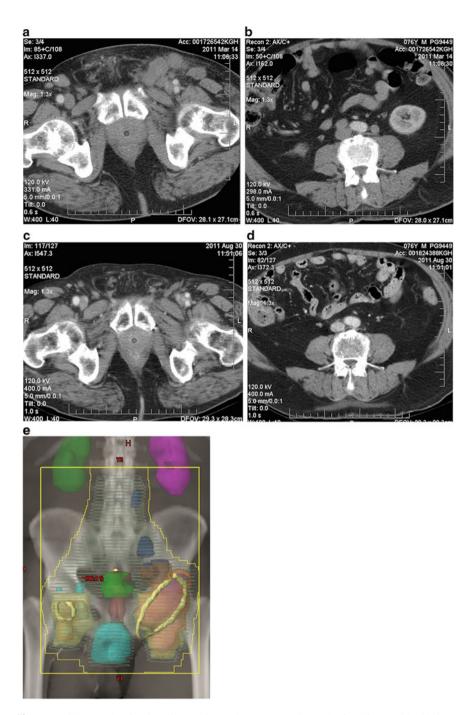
CT scan showing baseline staging and response at 5 months for 76-year-old with locoregionally advanced penile SCC treated with external beam radiotherapy and concurrent weekly cisplatinum. (a) Bilateral inguinal adenopathy (b) Adenopathy at level of L4. (c) Resolution of inguinal adenopathy 3 months after completion of treatment. (d) Resolution of lower para aortic adenopathy 3 months after completion of treatment fields with adenopathy contoured on CT and outlined with wire in the inguinal regions. 4500 cGy was delivered in 25 fractions over 5 weeks to the entire volume, followed by a boost to the right groin to 5500 cGy and to the left groin to 6500 cGy
